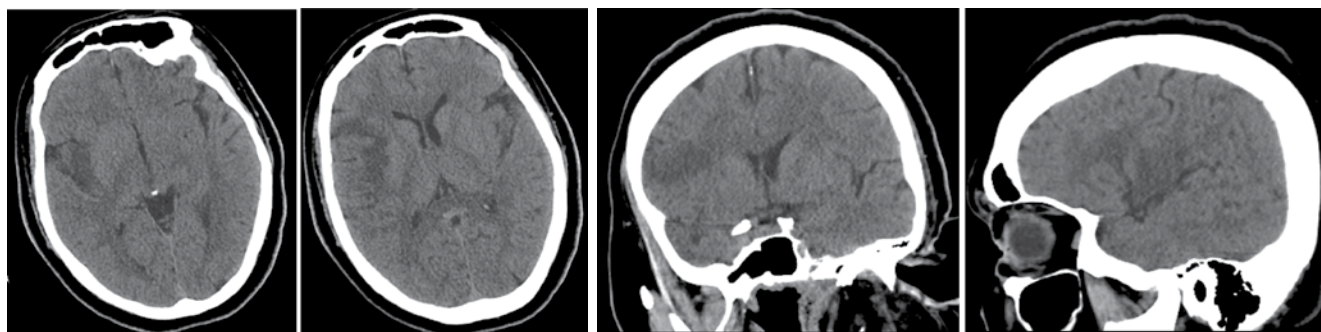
CT scan of the brain of patient F. at the time of admission to the RSC
